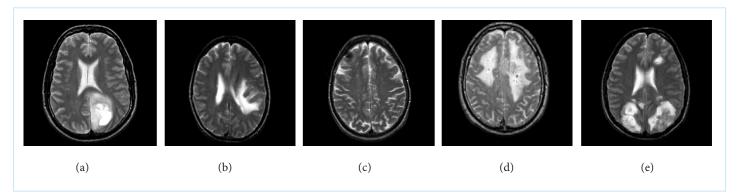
Five major brain tumors in MRI: a) Glioma, b) Meningioma, c) Metastatic adenocarcinoma, d) Metastatic bronchogenic carcinoma, and e) Sarcoma
